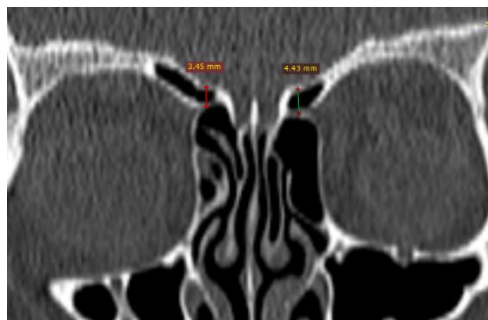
coronal CT scan: AEA hanging below the skull (distance given in millimeter)
